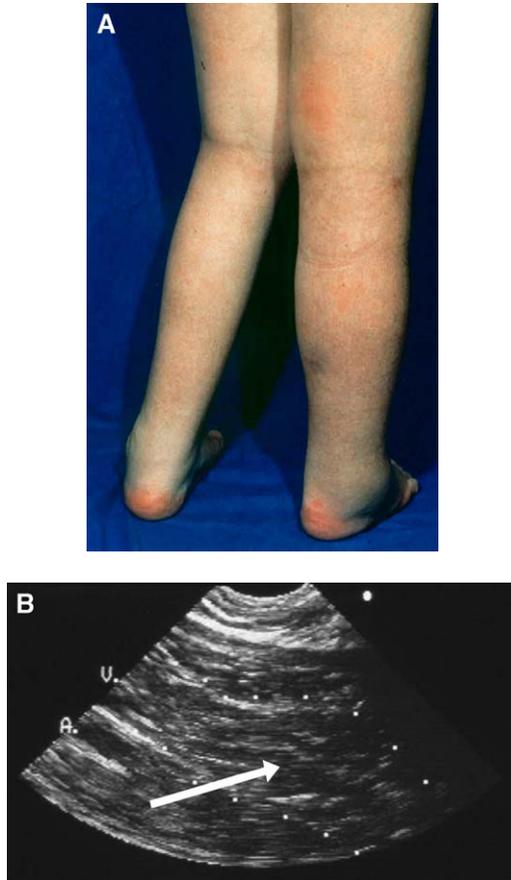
Right limb deep vein thrombosis in a 16-year-old boy with systemic JIA who had circulating aPL and was exposed to another thrombophilic factor (a prolonged plaster immobilization for a tibial fracture). (A) Diffuse edema of the right limb. (B) Doppler ultrasonography showing complete occlusion of a popliteal vein by a thrombus (*arrow*).
